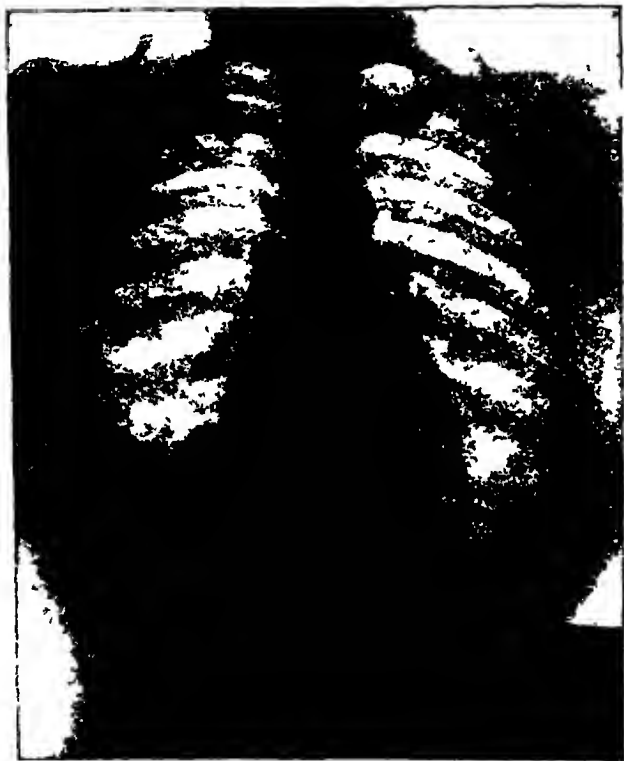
Case III. x-Ray taken November 19, 1924—seventy-seven days after antiluetic therapy had been instituted. There is almost a complete clearing of the lesion.
